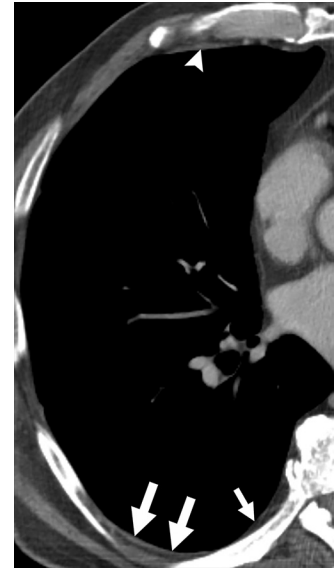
Normal CT appearance of the EPS. Axial CT image of the right side of the chest shows the intercostal stripe (large arrows) as a 1–2-mm-thick linear area of soft tissue in the anterolateral and posterolateral intercostal spaces, at the point of contact between the lung and chest wall. This stripe represents a combination of the visceral pleura, parietal pleura, extrapleural adipose tissue, ETF, and IIM, which is the main component. The intercostal stripe is incomplete in the anterior parasternal and posterior paravertebral areas of the chest wall. The paravertebral line (small arrow) in the posteromedial aspect of the chest wall represents the ETF and the parietal and visceral pleurae. The transversus thoracis muscle (arrowhead) is seen along the parasternal region of the chest wall as a stripe of soft-tissue attenuation in the same plane as the IIM.
